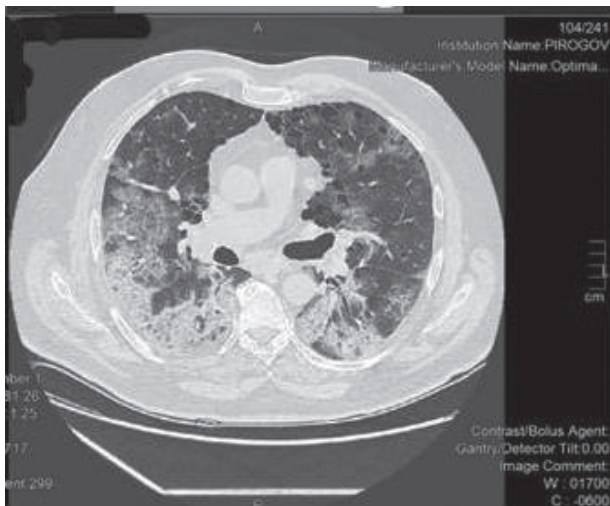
CT-data on changes in the lung parenchyma according to the type of atypical pneumonia with viral genesis, severe degree (50–75% involvement). Emphysematous bullae.
